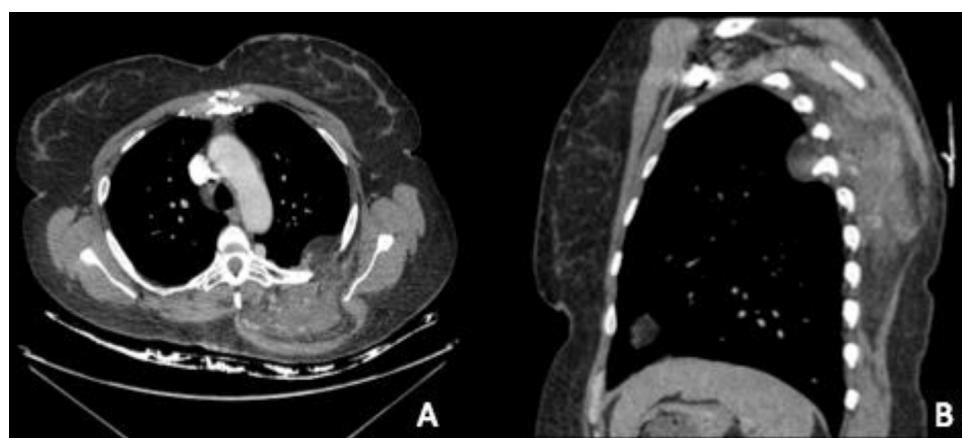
CT scan showing chest wall angiomatosis lesion with intrathoracic extension in A) axial and B) sagittal views.
